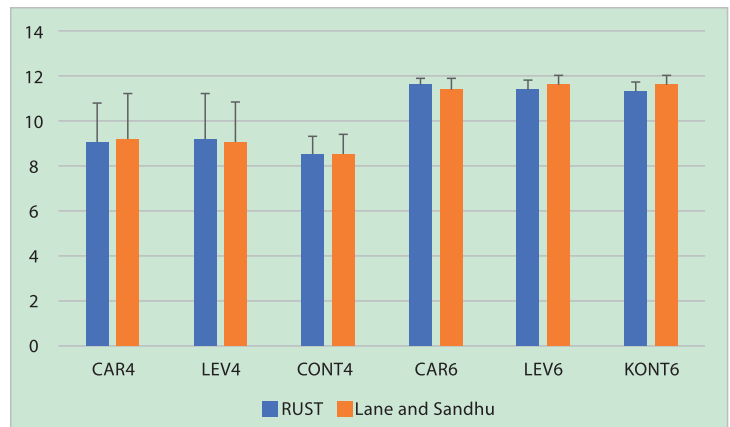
Statistical results of roentgenographic measurements.
